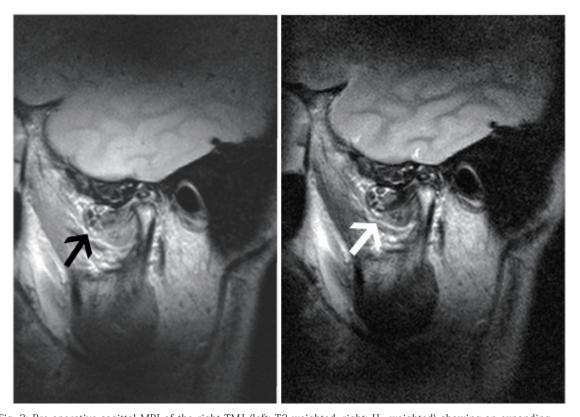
Pre-operative sagittal MRI of the right TMJ (left: T2 weighted, right: H+ weighted) showing an expanding articular cavity and indicating a high signaling lesion. (Arrows)
